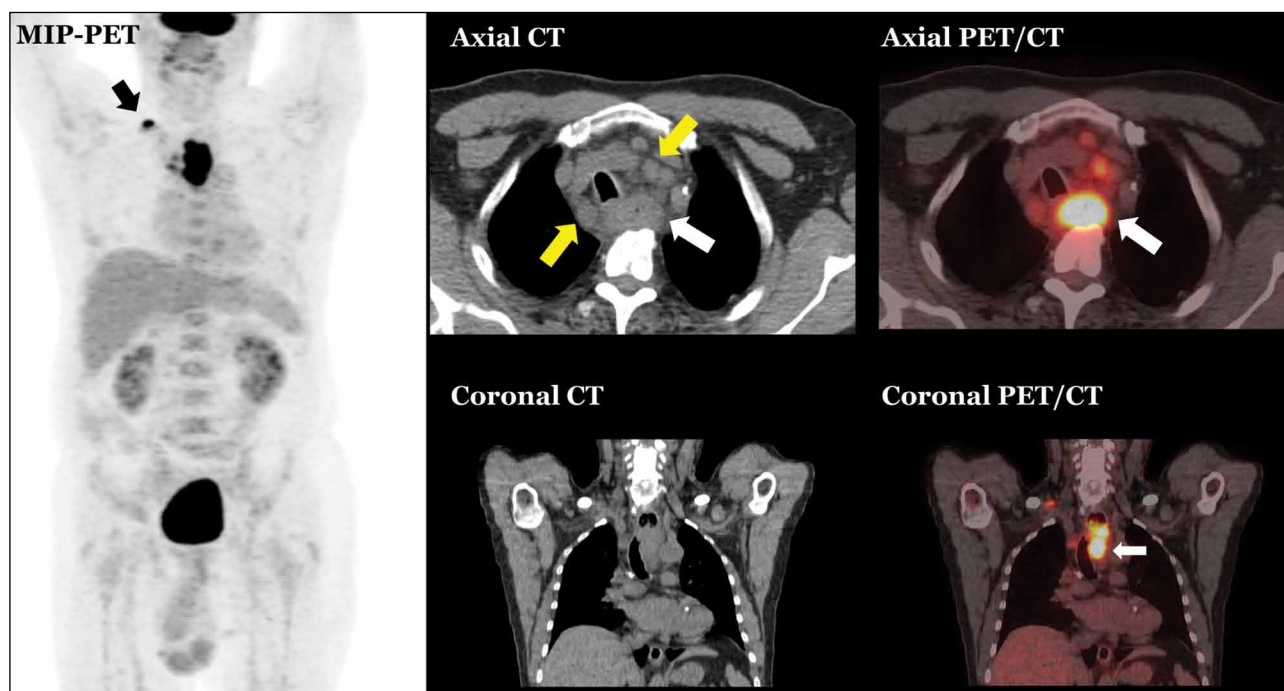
Advanced T-stage oesophageal cancer with nodal metastases. Primary tumor (white arrow) presenting as abnormal concentric wall thickening with adjacent peri-oesophageal fat stranding and displacement of the trachea to the right. There are FDG-avid nodes in the mediastinum (yellow arrow) and in the right supraclavicular fossa (black arrow).
